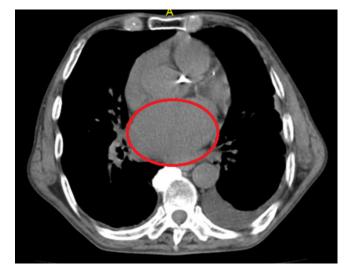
Computed tomography of the heart. The left atrium is a posterior structure and usually it is not visible on a chest X-ray. In case of dilation, it will become visible.
